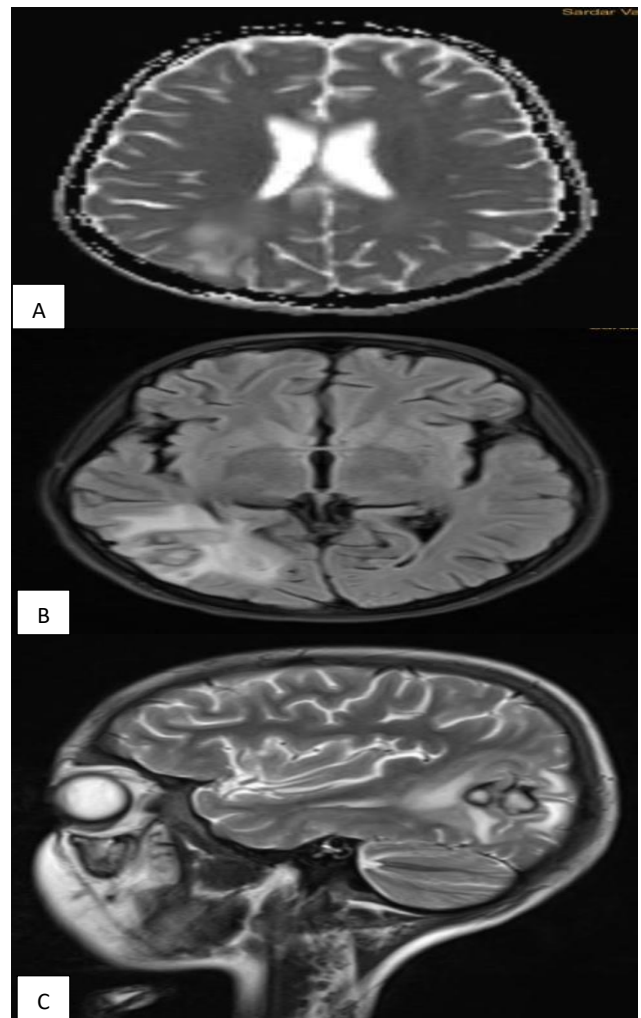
(A-C): MRI brain with contrast of well-defined approximately 30×27×21 mm (AP×TR×CC) sized peripherally rim enhancing altered signal intensity lesion with perilesional edema in right parietal lobe.
